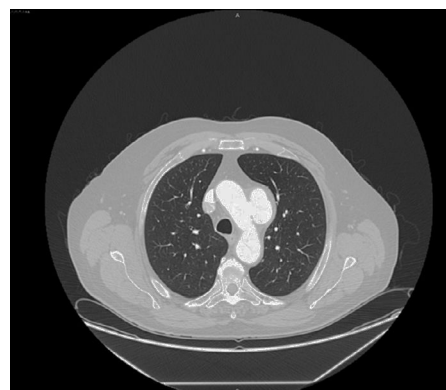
Contrast-enhanced thoracic computed tomography with frontal reconstruction, showing a saccular aneurysm of the aortic arch.
